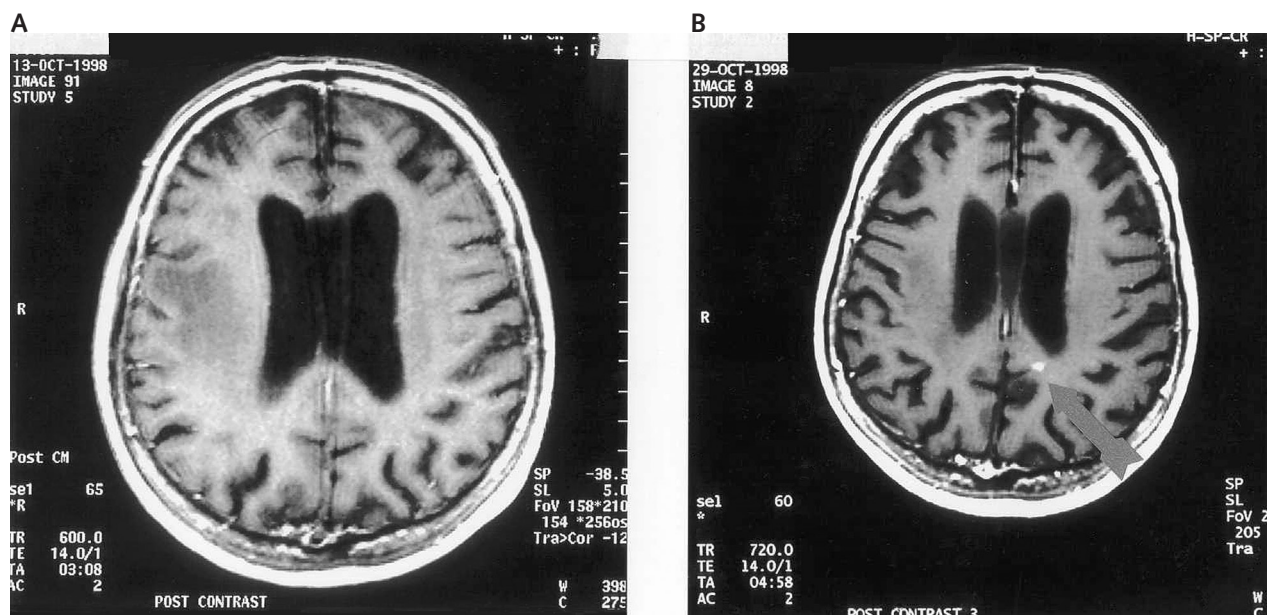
MR imaging to reveal lesion in left occipital lobe. A. Conventional MR with single-dose gadolinium. B. Triple-dose gadolinium-enhanced MR on the day of gamma knife planning reveals a contrast enhancing lesion in the left occipital lobe (immediately posterior to the ventricle) that was not visualized on the conventional study 2 weeks earlier.
